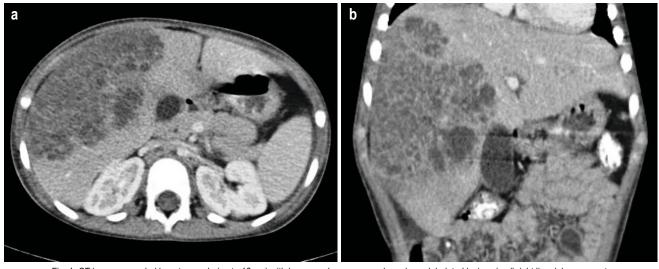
CT images revealed hepatomegaly (up to 16 cm) with large non-homogenous, hypodense lobulated lesions in all right liver lobe segments and in S1 and S4 segments. Axial view (a) and coronal view (b).
